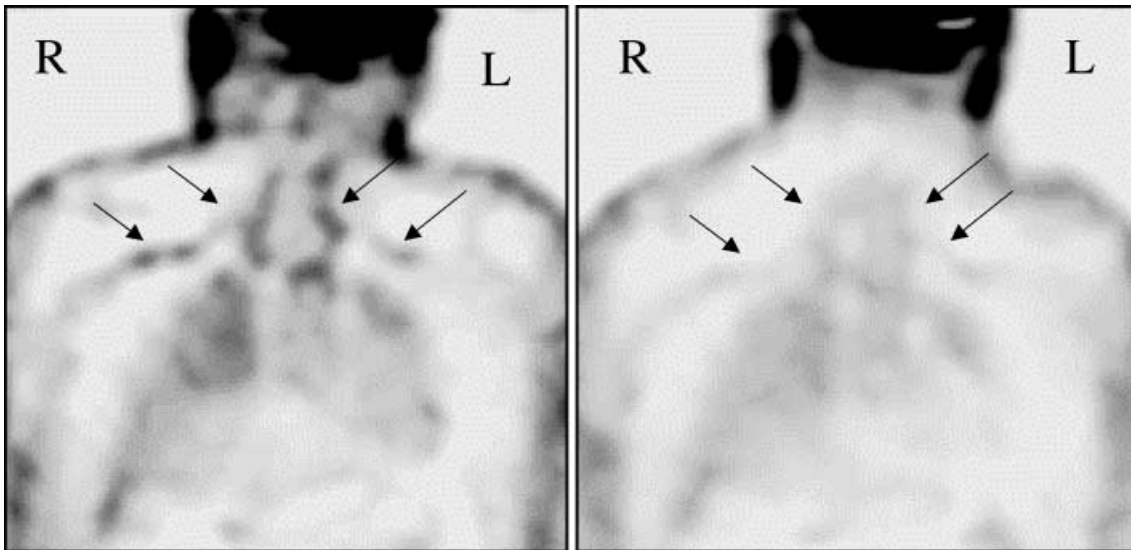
A patient with fever of unknown origin. FDG PET coronal images (left) show increased FDG uptake in the large thoracic vessels and arteria carotis communis (arrows), suggesting arteritis. The arteria temporalis could not be visualized due to the proximity of the brain (high normal FDG uptake). Subsequently, arteria temporalis biopsy was performed, revealing giant cell arteritis. A follow-up scan (right) 6 weeks after initiation of corticoid therapy shows a decrease in the inflammatory process
